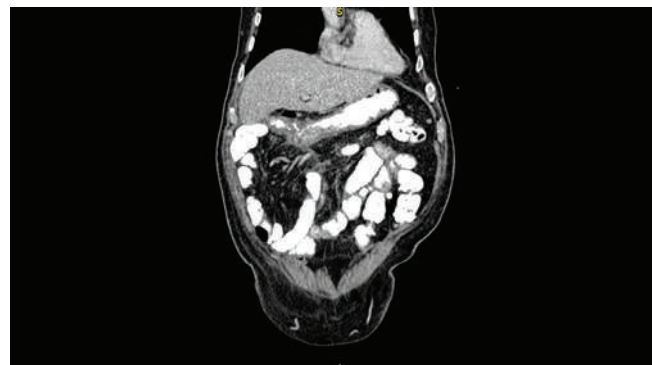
Control CT scan taken at the end of treatment and passage of the contrast medium into the small bowel loops.
